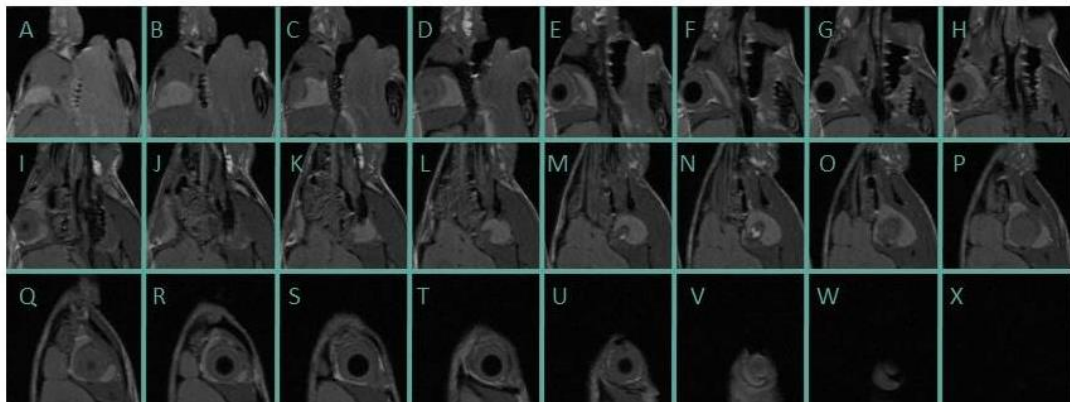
A series of contiguous T2w MRI with axial slices guide.
